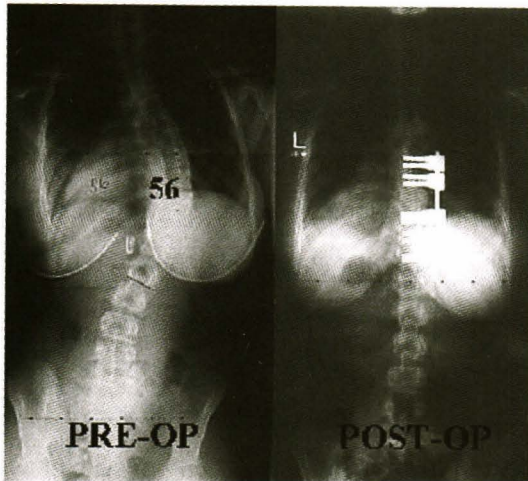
Radiographic demonstration of coronal plane correction by KASS device, an excellent curve correction was achieved with fewer segment fusion compare to posterior approach.
